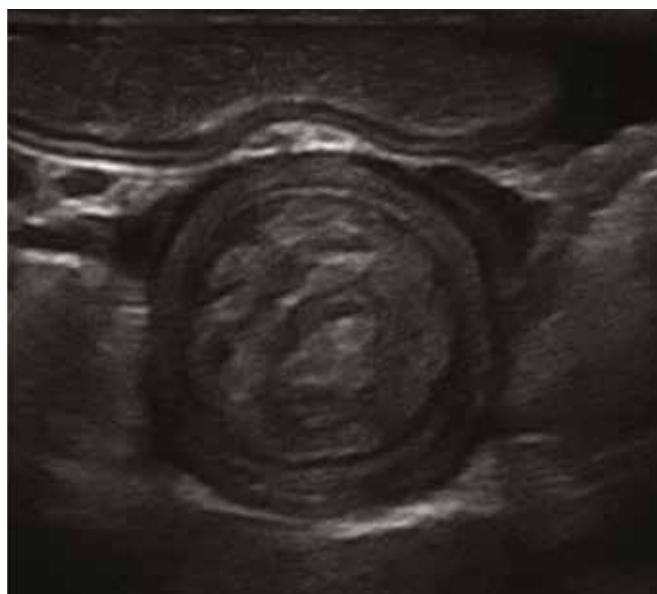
Ultrasound image of an intestinal intussusception showing concentric rings in the transverse section.
